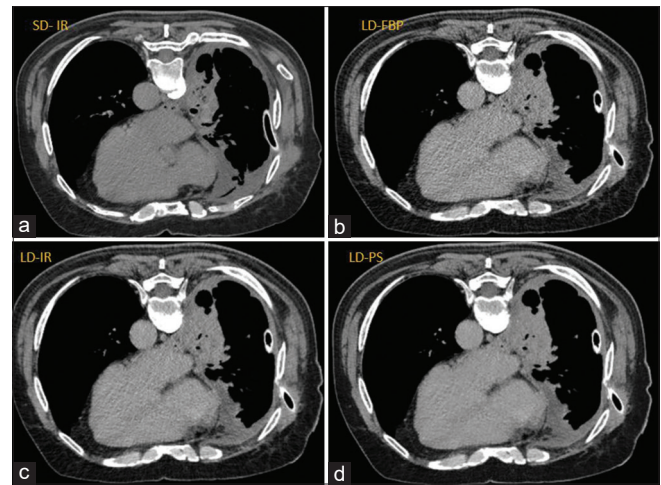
Computed tomography (CT)-guided biopsy procedure performed on Scanner B with native iterative reconstruction (IR) – iDose, planning phase (a) at standard dose (SD) (300 mA and 120 kV) and the targeting phase at 103 mA and 120 kV (30% of SD) and reconstructed by filtered back projection (FBP) (b), IR (c), and PixelShine (PS) reconstruction (d). PS image has lower noise than the FBP and IR images and even the SD image. SD: Standard dose, IR: Iterative reconstruction, LD: Low dose, PS: PixelShine, FEB: Filtered back projection
